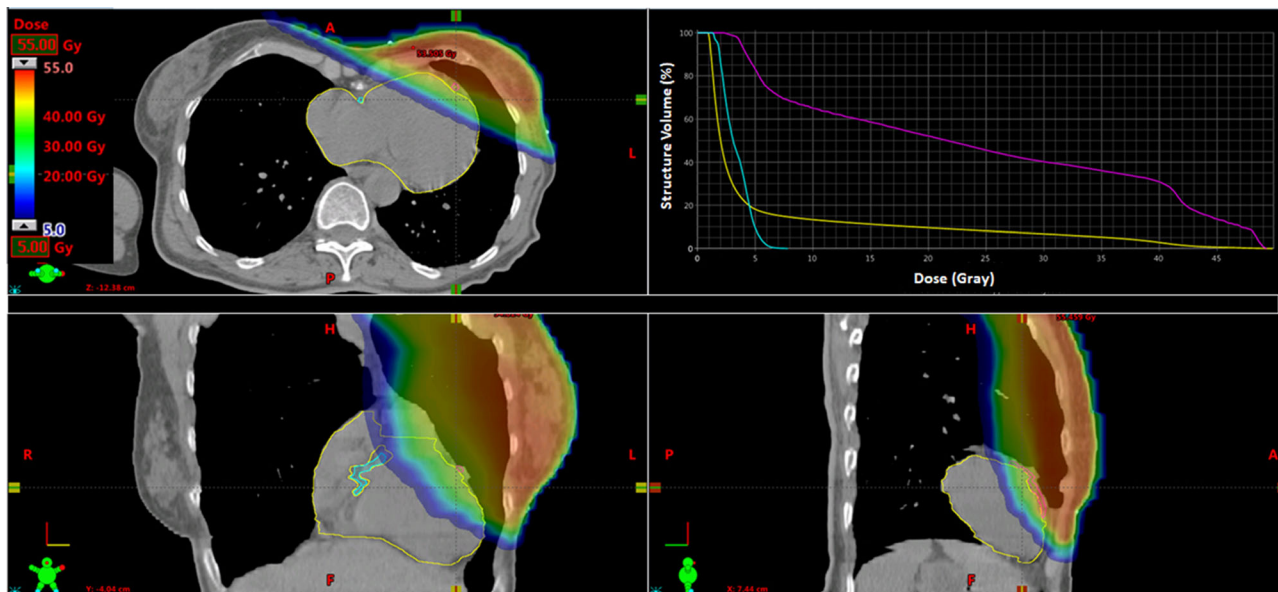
Treatment plan for patient treated for left-sided breast cancer, treated with breast conserving surgery. Axial (upper left), coronal (lower left), and sagittal (lower right) CT-slices. Doses shown from low (blue) to high (= prescribed dose) (red). Dose-volume histogram (upper right) shows radiation doses to the heart (yellow), the left anterior descending coronary artery (LAD) (pink) and the right coronary artery (RCA) (cyan).
